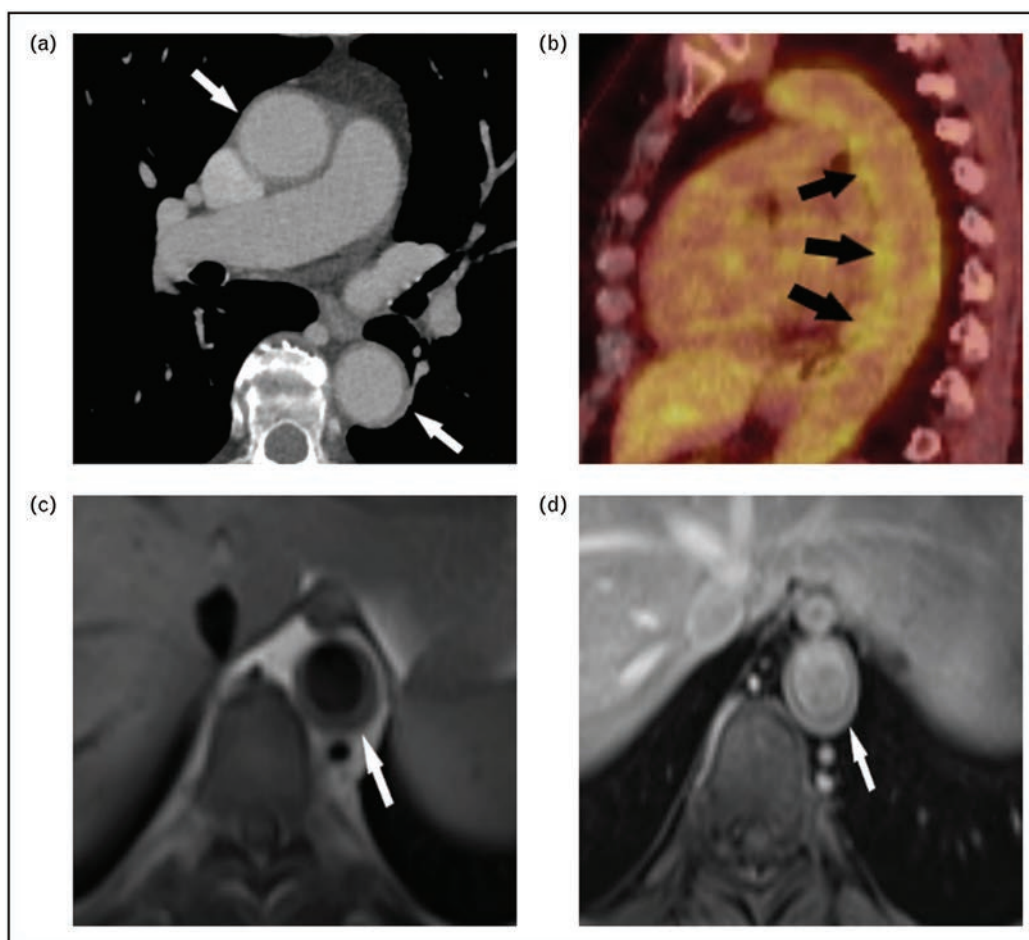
Imaging findings of aortitis. (a) Axial contrast enhanced CT image with mild circumferential wall thickening and enhancement in the involving both the ascending and descending thoracic aorta (arrows), (b) FDG uptake on PET (arrows) descending aorta on sagittal fusion PET-CT images. (c) MR findings of aortitis include wall thickening on axial black blood T1-weighted; (arrow) and wall enhancement (d) on axial T1-weighted fat saturation post contrast, (arrow).
